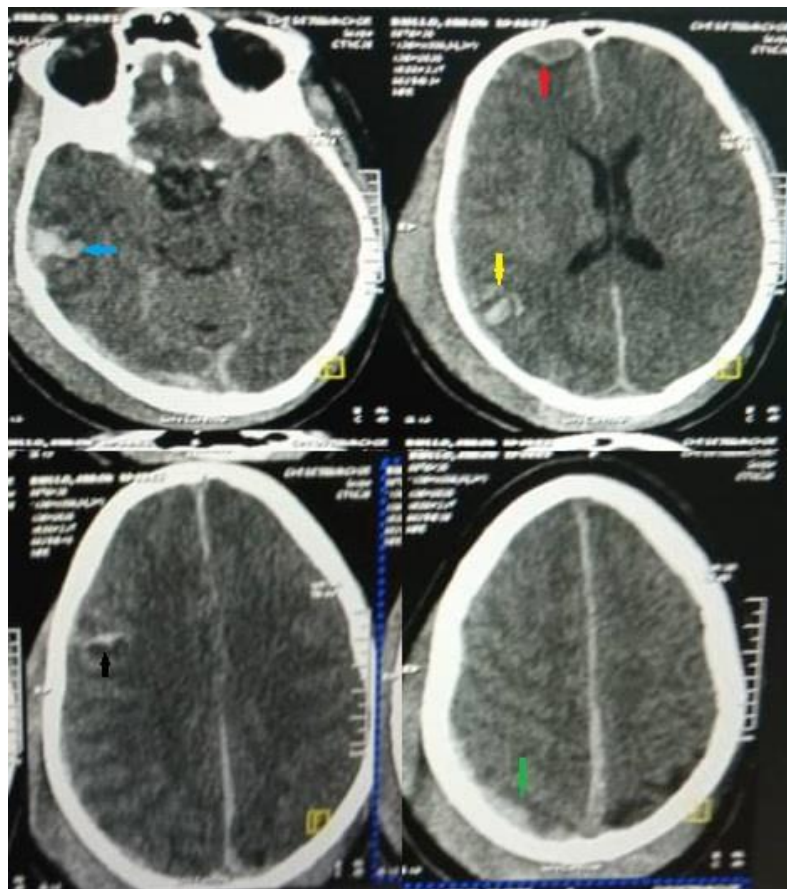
Brain CT Scan without injection of contrast material showing five types of posttraumatic hemorrhagic intracranial lesions: a right frontal epidural hematoma (red arrow), a subdural parieto-occipital hematoma (green arrow), an intraparenchymal hematoma (blue arrow), a right posterior parietal contusion (yellow arrow), a sub arachnoid hemorrhage (black).
